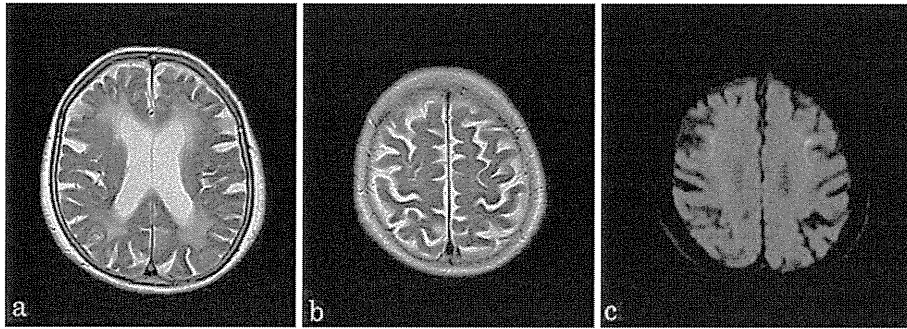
a, b T2-weighted MRI showing dilation of the lateral ventricle, moderate cerebral atrophy, and high-intensity areas in the cerebral white matter. c DWI indicated high signal intensity in the corticomedullary junction.
